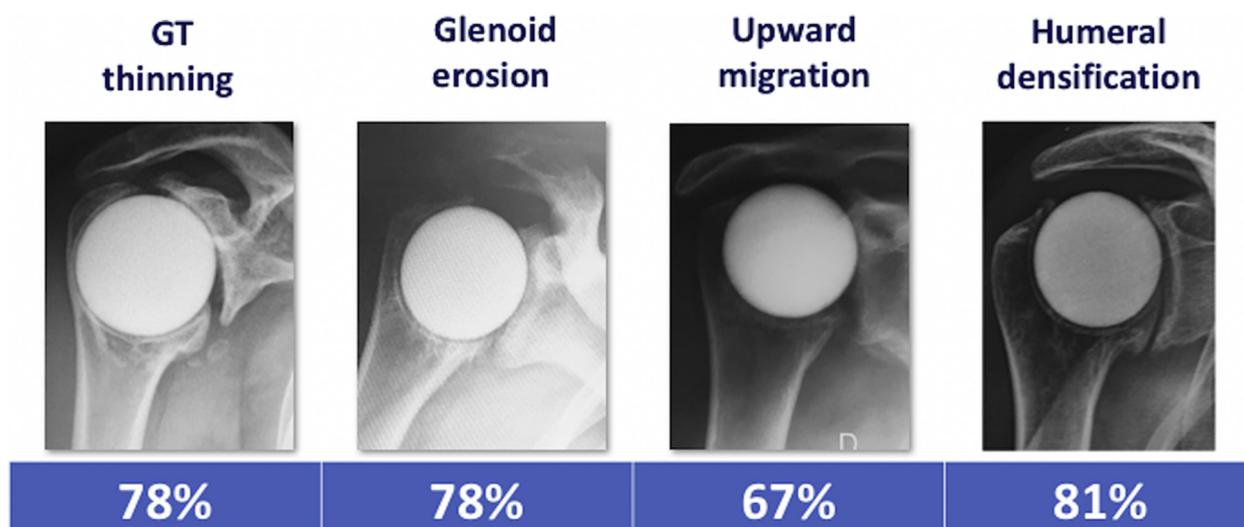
Horizontal plane with radiographic results at last follow-up.
